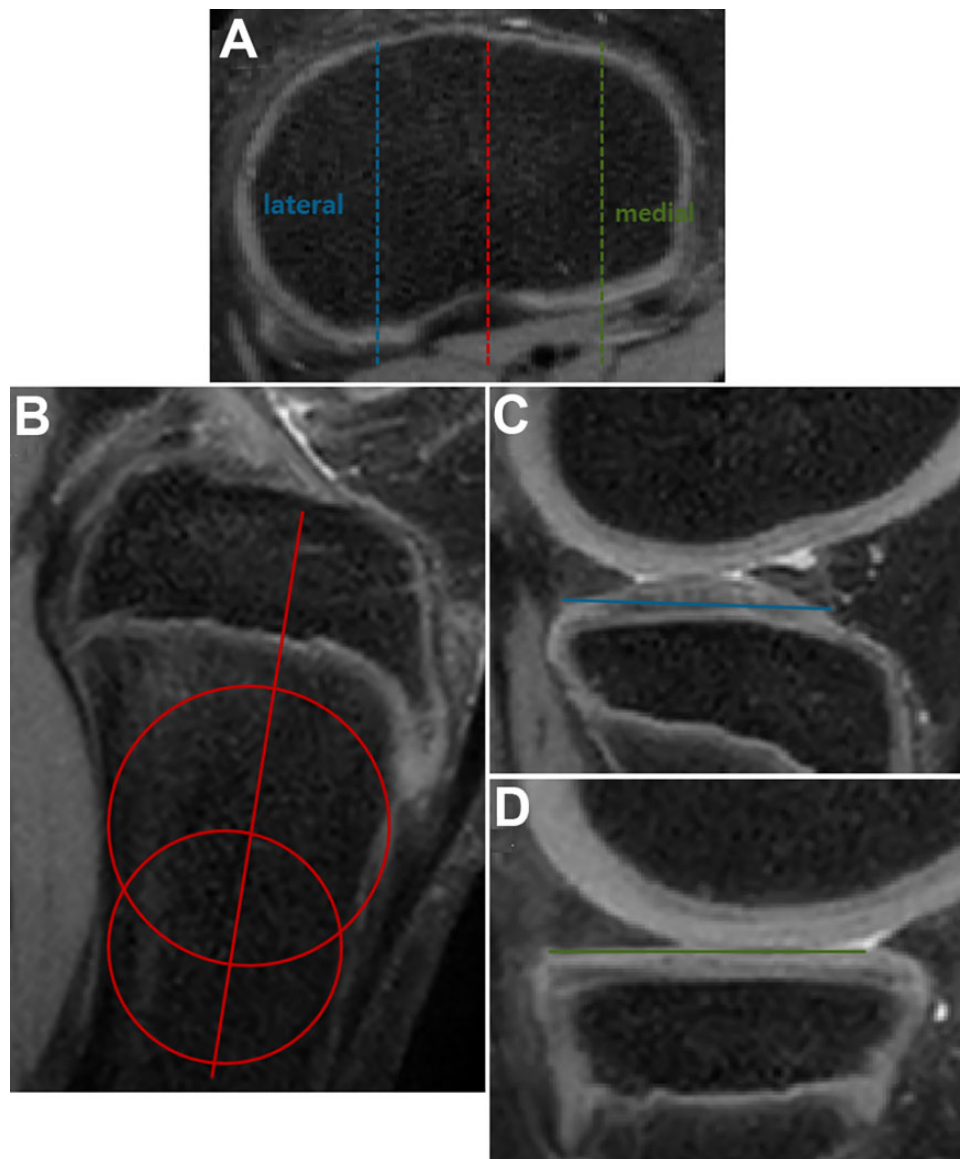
Measuring the tibial curvature on magnetic resonance imaging. (A) Three sagittal sections were created on the proximal transverse plane of the tibia: the middle section of the transverse tibia (dashed red line), the lateral tibial plateau (dashed blue line), and the medial tibial plateau (dashed green line). (B) On the sagittal section of the dashed red line in (A), the longitudinal tibial axis (solid red line) was determined by connecting the centers of 2 best-fit circles. (C) The lateral posterior tibial slope was determined by connecting the anterior aspect of the anterior horn and the posterior aspect of the posterior horn of the meniscus on the sagittal plane of the dashed blue line in (A). (D) The medial posterior tibial slope was determined by connecting the posterior aspect of the anterior horn and the posterior aspect of the posterior horn of the meniscus on the sagittal plane of the dashed green line in (A). The tibial lateral and medial anteroposterior lengths were also determined on the sagittal plane. The posterior tibial angle was determined as the angle between the posterior tibial slope line and longitudinal tibial axis.
